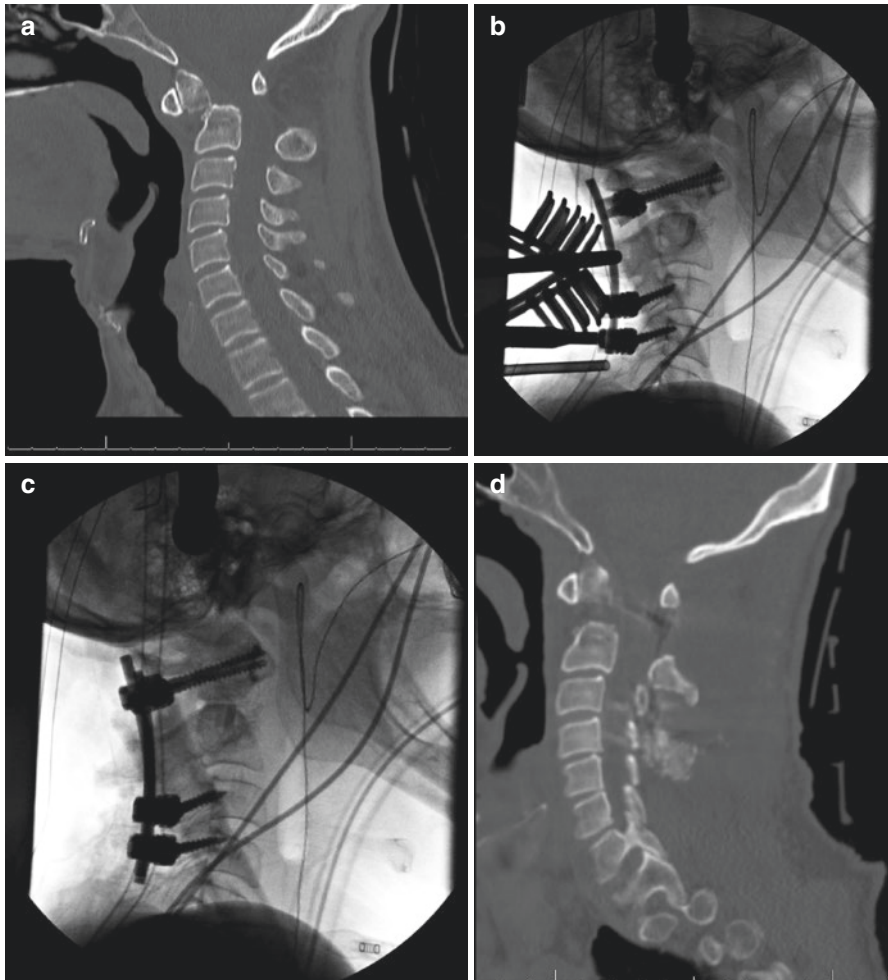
A 57-year-old male presented with a history of falls, neck pain, and progressive cervical myelopathy. CT shows a severely anteriorly displaced dens fracture causing upper cervical stenosis (a). Intraoperatively, the fracture was partially reduced before final placement of the rod (b). Final reduction with the rod allowed adequate fracture reduction (c, d)
